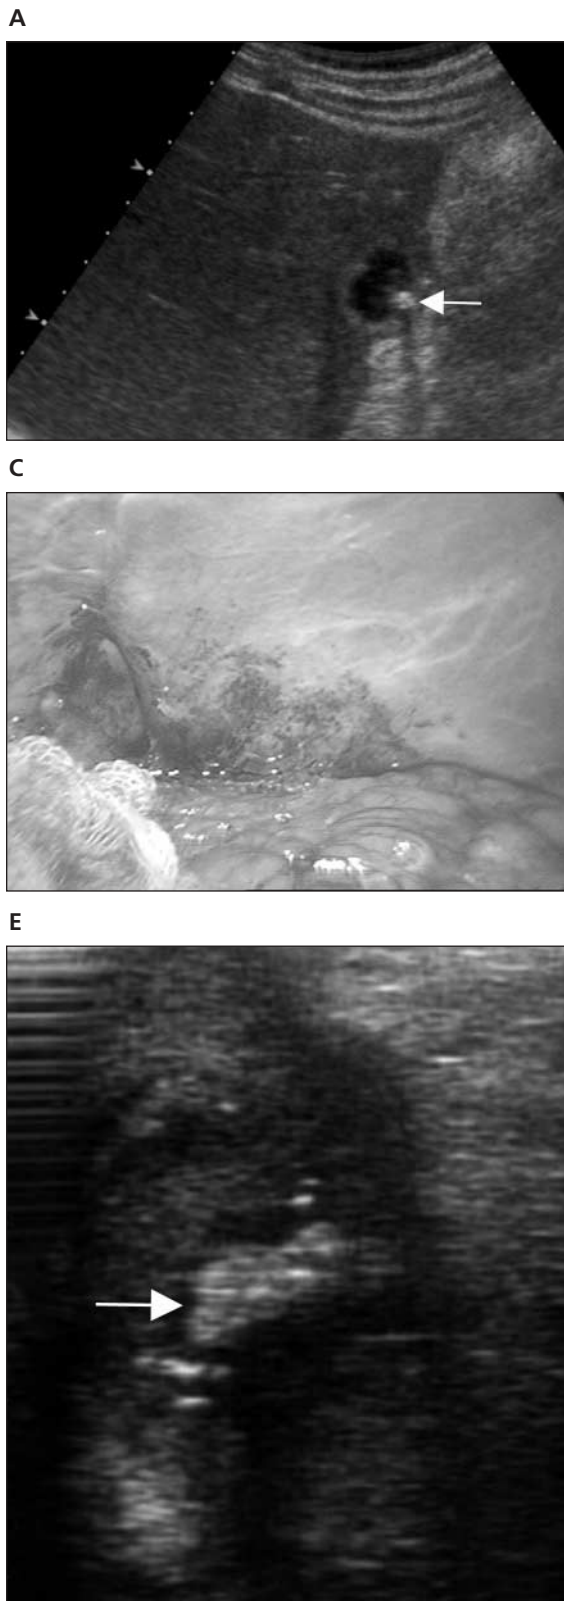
Appendicolith in a right subhepatic abscess in a 25-year-old man who had undergone laparoscopic appendectomy. A and B, Percutaneous transabdominal ultrasonography (A) and CT (B) show the retained appendicolith (0.8 cm) (arrows) in an abscess pocket (3.6 cm) at the right hepatorenal fossa. C, On laparoscopy, a severe peritoneal adhesion is shown in the right subhepatic space. This makes surgical localization of an appendicolith difficult because the right hepatorenal fossa is obscured. D, The LUS probe is searching the appendicolith in the right subhepatic space. E, An LUS image shows a hyperechoic stone with posterior acoustic shadowing in the abscess pocket (arrow). F, Removal of the appendicolith (arrow) after aspiration of pus.
